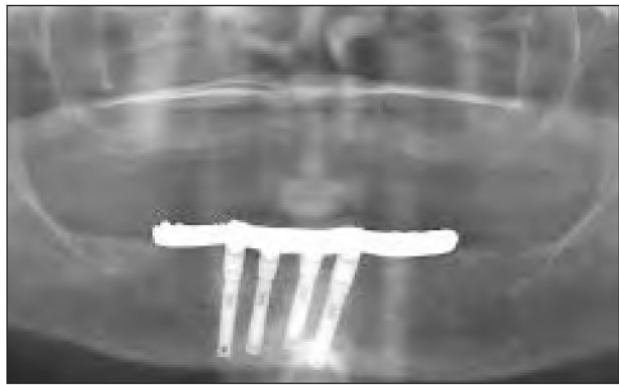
Panoramic radiograph of the same patient in 2006, 18 years later.
